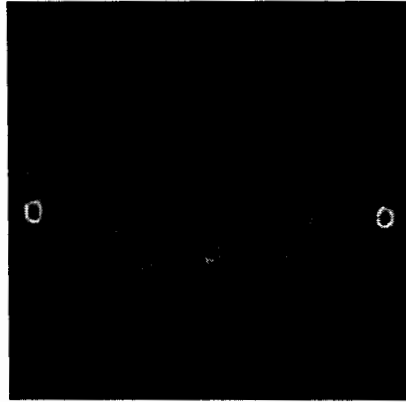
Fusion of CT and MR images of Pelvis by PCA
